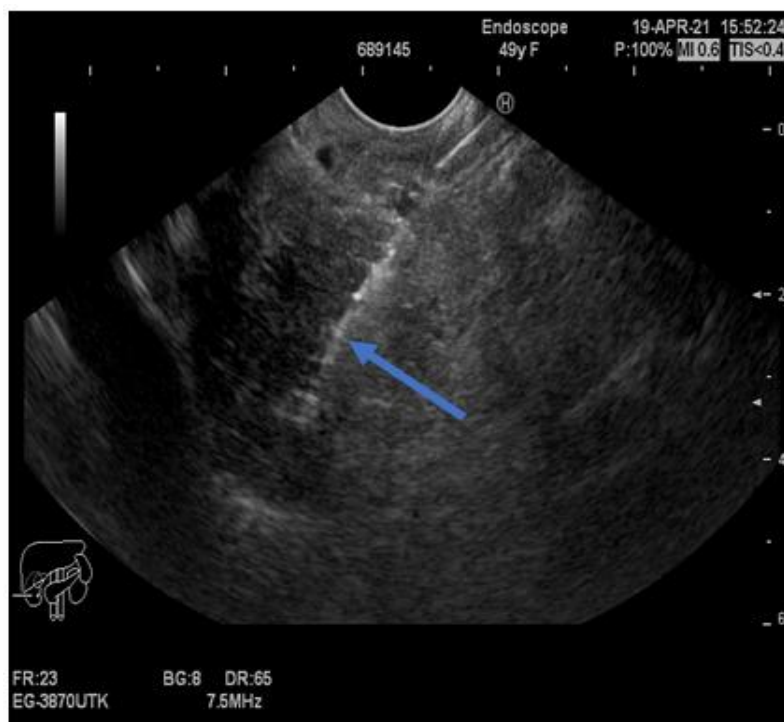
Ultrasound endoscopic guided fine-needle aspiration of the pancreatic masse (blue arrow)
